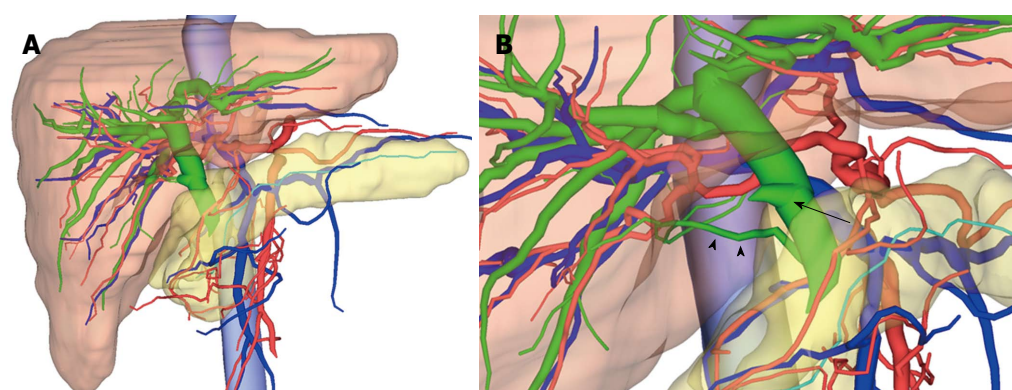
3-dimensional images by integrating multidetector computed tomography and magnetic resonance cholangiopancreatography images. A: 3-dimensional (3D) image view from the front side of the patient. The red colour represents the arteries, the blue represents the veins and the portal vein, the green represents the biliary duct, and the turquoise represents the pancreatic duct. We were able to observe that the common and intrahepatic bile ducts were dilated; B: From the 3D image view from the patient's right side, the accessory bile duct from the caudate lobe connecting to the intrapancreatic bile duct (arrowheads) was easily recognisable. The cystic duct (arrow) has branched from the middle bile duct. We were able to determine that the injured site was the accessory bile duct from the caudate lobe.
